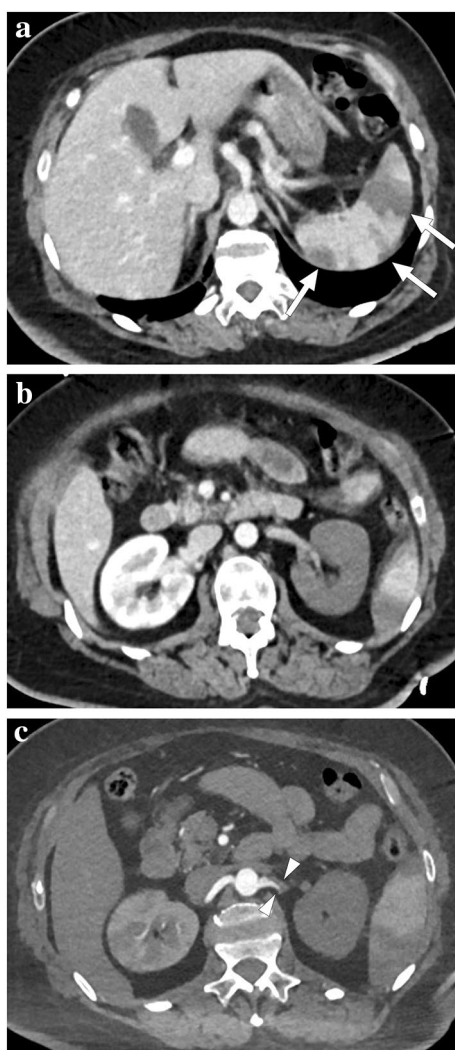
A 57-year-old male patient with multiple comorbidities and severe COVID-19 infection necessitated intensive care unit admission. The patient expressed sudden-onset dyspnea and severe left upper quadrant pain during follow-up. a–c Contrast-enhanced thoracoabdominal CT revealed deep vein thrombosis (not shown), massive pulmonary thromboembolism (not shown), multiple splenic infarcts (arrows, a), global devascularization of the left kidney (b) secondary to the occlusion of the left renal artery (arrowheads, c), and small-sized, patchy right renal infarcts (not shown). Despite maximum supportive care, the patient continued to deteriorate, developed multiple embolic infarcts in the brain (not shown), and expired shortly afterward
